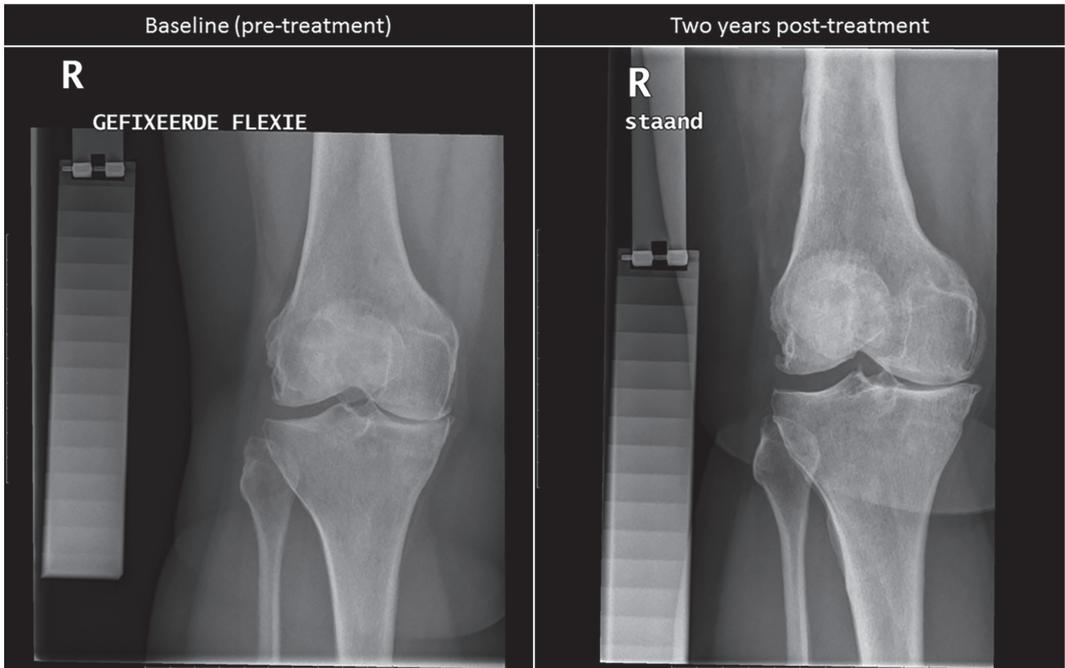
Representative radiograph of a patient before and 2 years after knee joint distraction treatment.
